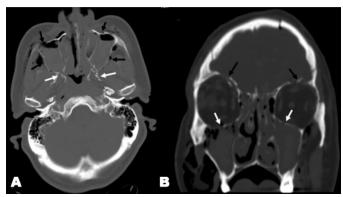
CT scan of facial bones axial view (A) showing fracture of bilateral pterygoid plates [white arrows] anterior and posterolateral walls of maxillary sinuses [black arrows]. Coronal image (B) shows bilateral orbital floor fractures [white arrows] and orbital roof fractures [black arrows]
